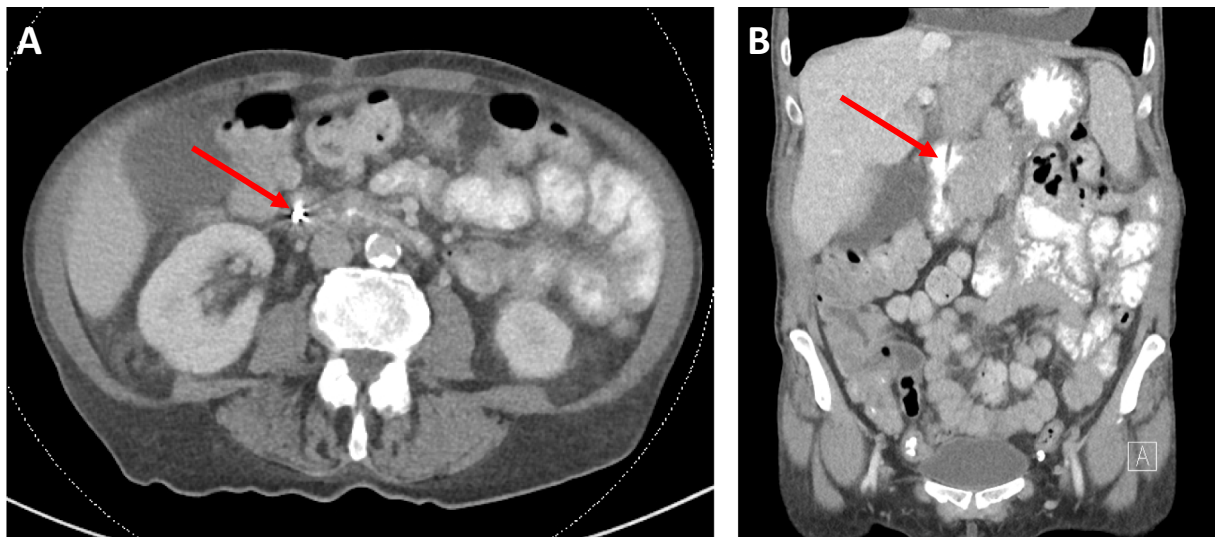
Axial computed tomography (CT) view (A) showing the radio-opaque tip of the ingested pen. Coronal CT section (B) demonstrating where the pen perforates through the first part of the duodenum.
